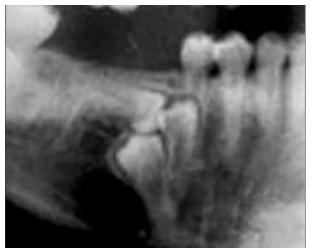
Cropped panoramic radiograph of supernumerary peridens.
